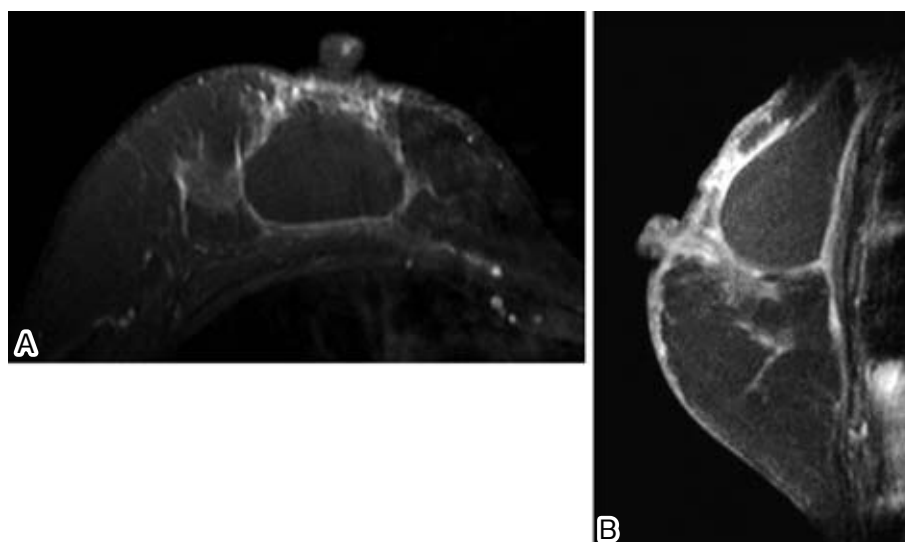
Contrast-enhanced subtracted breast magnetic resonance images in axial (A) and sagittal (B) planes show capsule wall-like contrast enhancement surrounding the homogenous nonenhanced mass, which is thought to be filling content.
